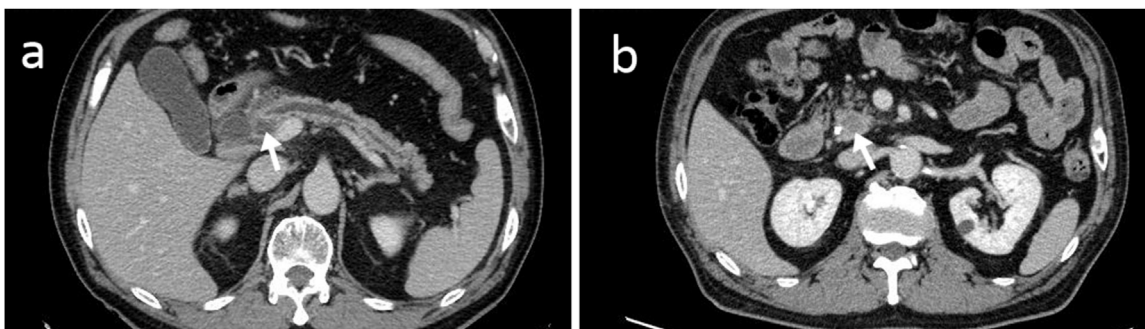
(a) Contrast-enhanced computed tomography findings at the time of admission showing bile and pancreatic duct dilation and increased radiodensity around the pancreatic head. A pancreatic pseudocyst could also be observed (arrow). (b) Contrast-enhanced computed tomography after treatment for acute cholangitis and pancreatitis showing tumor (arrow) in the main pancreatic duct at the pancreatic head. The high-density structure in the bile duct was due to the endoscopic retrograde biliary drainage tube. Note the improvements in dilation of the bile and pancreatic ducts.
